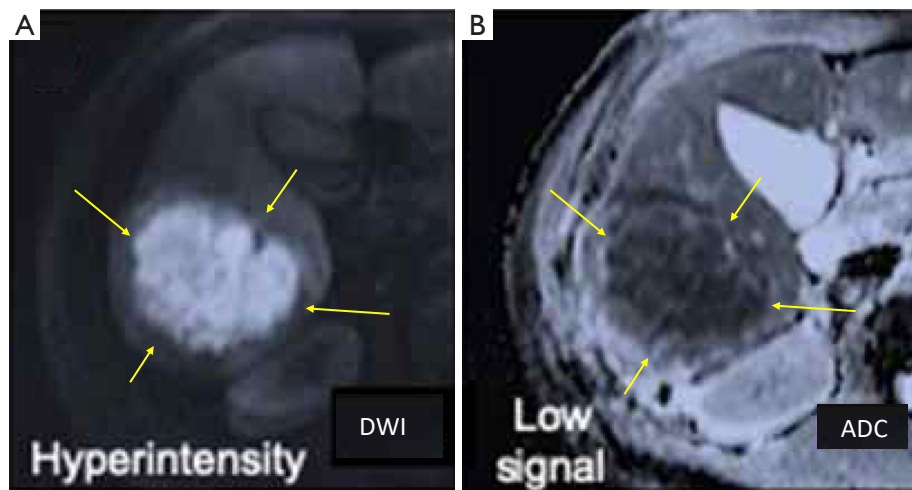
DWI (A) and ADC (B) map of a liver pyogenic abscess (arrows). The abscess liquid has very high DWI signal and very low ADC. It appears unreasonable that the abscess content has a so low ADC measure. Adapted from Castillo and Manterola (8). ADC, apparent diffusion coefficient; DWI, diffusion-weighted imaging.
